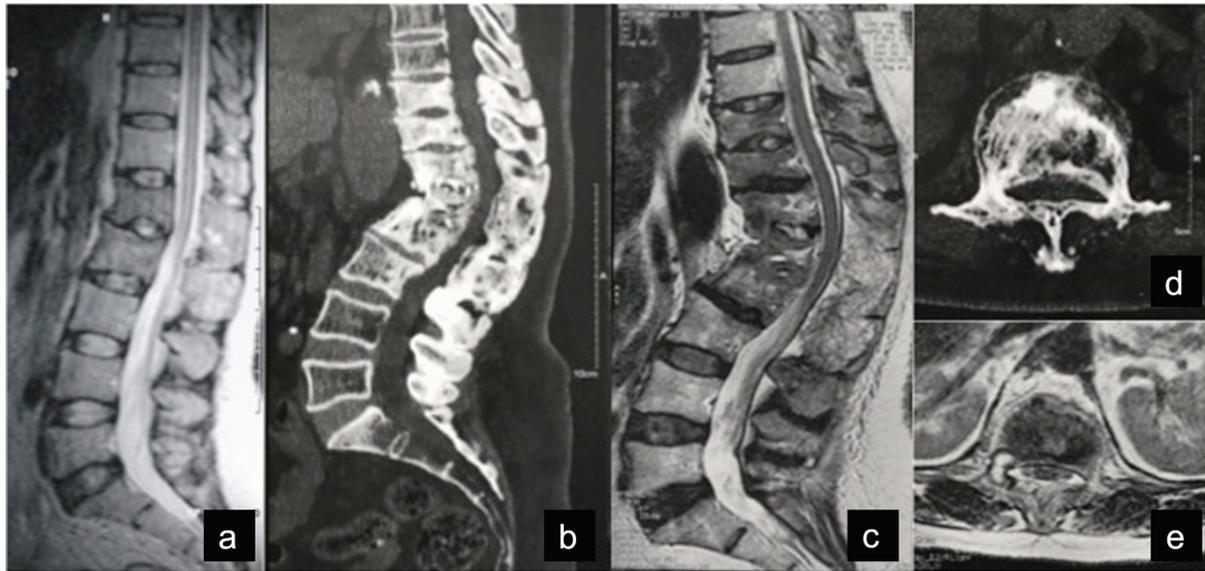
A 64-year-old female was diagnosed with Pott disease and treated conservatively. The lumbar spine magnetic resonance imaging (MRI) exam – T2 sequence – shows a hypointense signal at L1 and L2 (a). Ten years later, the computed tomography (CT) and the MRI (b, c, d and e) show thoracolumbar (TL) junction kyphosis, bone sclerosis from T10 to L3, and spinal canal narrowing.
